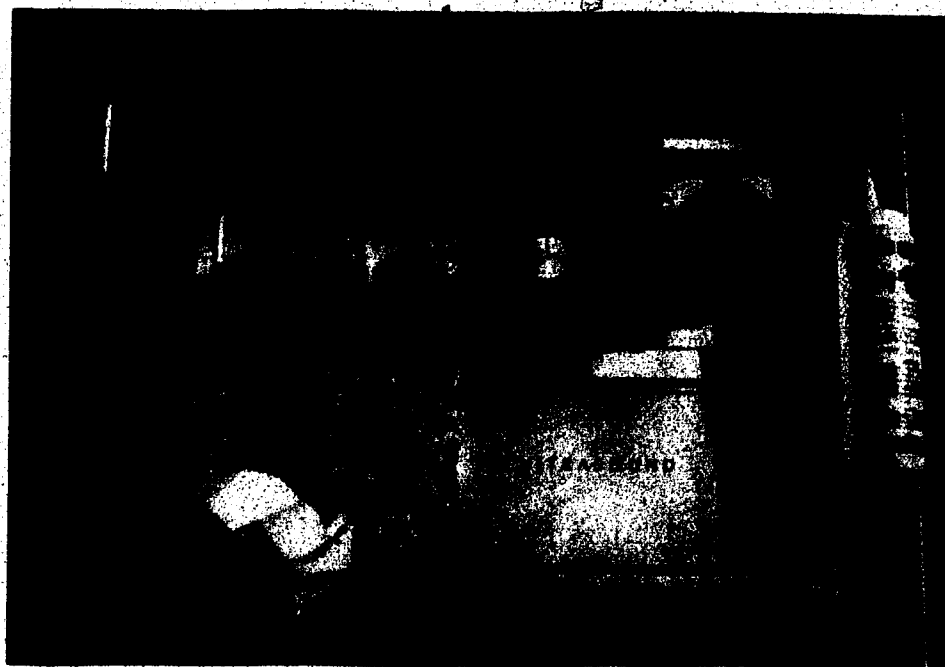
OVERHEAD VIEW OF ULTRASOUND MACHINE
